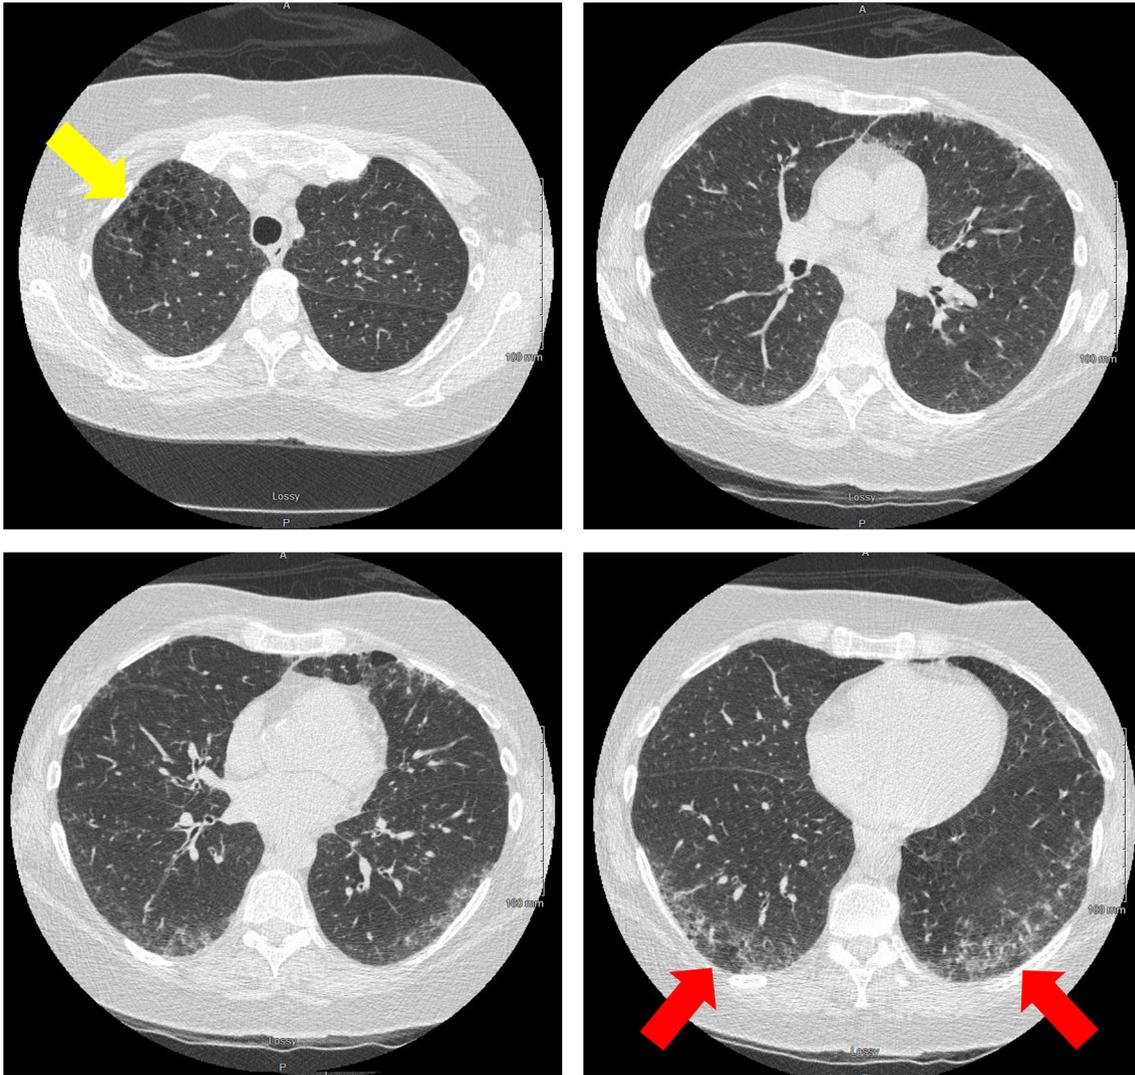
Chest CT demonstrating apical emphysematous change (yellow arrow) and peripheral ground glass attenuation and subpleural intralobular interstitial thickening (red arrows).
